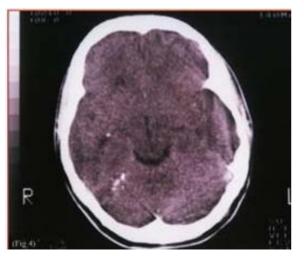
CT-scan of the brain, revealing calcifications in the right cerebellum and paraventricular area.
